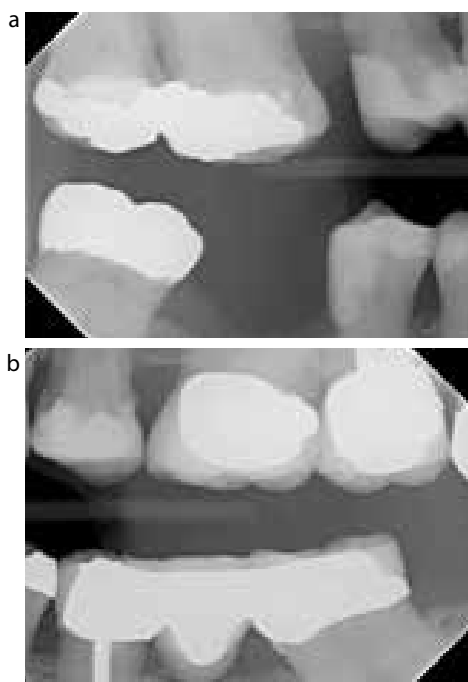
(a) Right bitewing radiograph taken 02/06. (b) Left bitewing radiograph taken 02/06.
